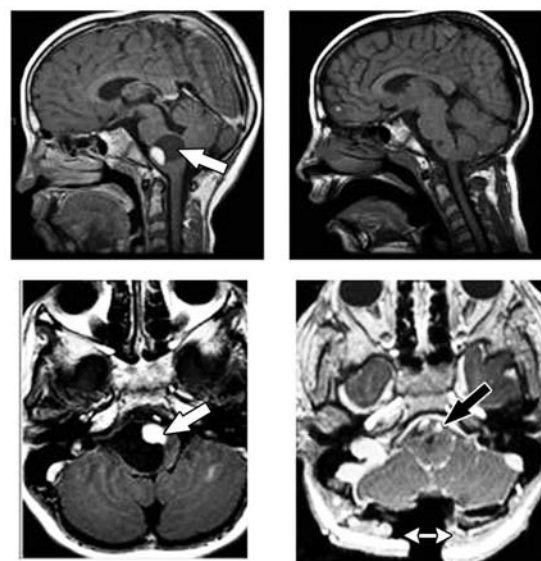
Focal medullary glioma (white arrows) in a 9-year-old child. Sagittal (top) and axial (bottom) T1-weighted contrast enhanced images before (left) and after (right) complete resection and return of vertebral arteries to normal position (black arrow) as seen in an intraoperative MRI (skin is still open, double arrow).
